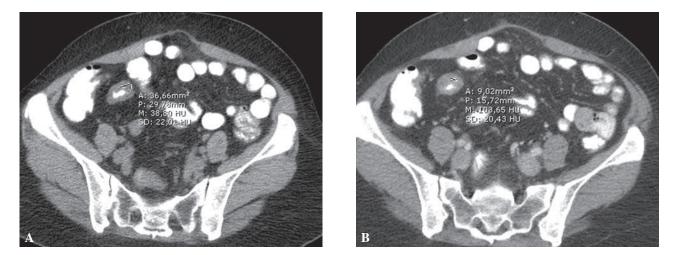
A 47 year-old female with terminal ileitis (patient #2 of Table 2). Axial (A) pre- and (B) post-contrast CT images reveal a thickened ileal wall (pre-contrast value ; +38 HU, post- contrast value ; +103 HU).
